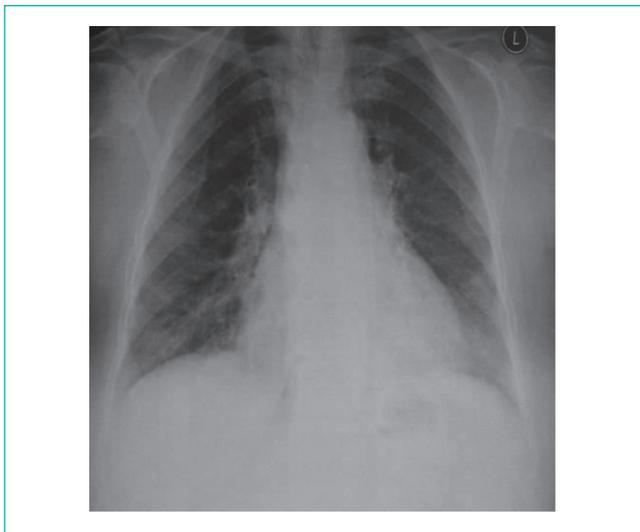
Chest x-ray appears hilum enlargement.
